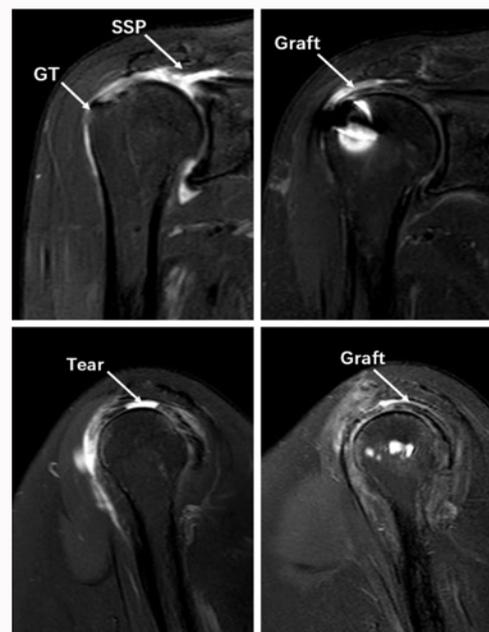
Patient one: MRI a) preoperative oblique coronary position; b) postoperative oblique coronary position; c) preoperative oblique sagittal position; d) oblique sagittal position.
